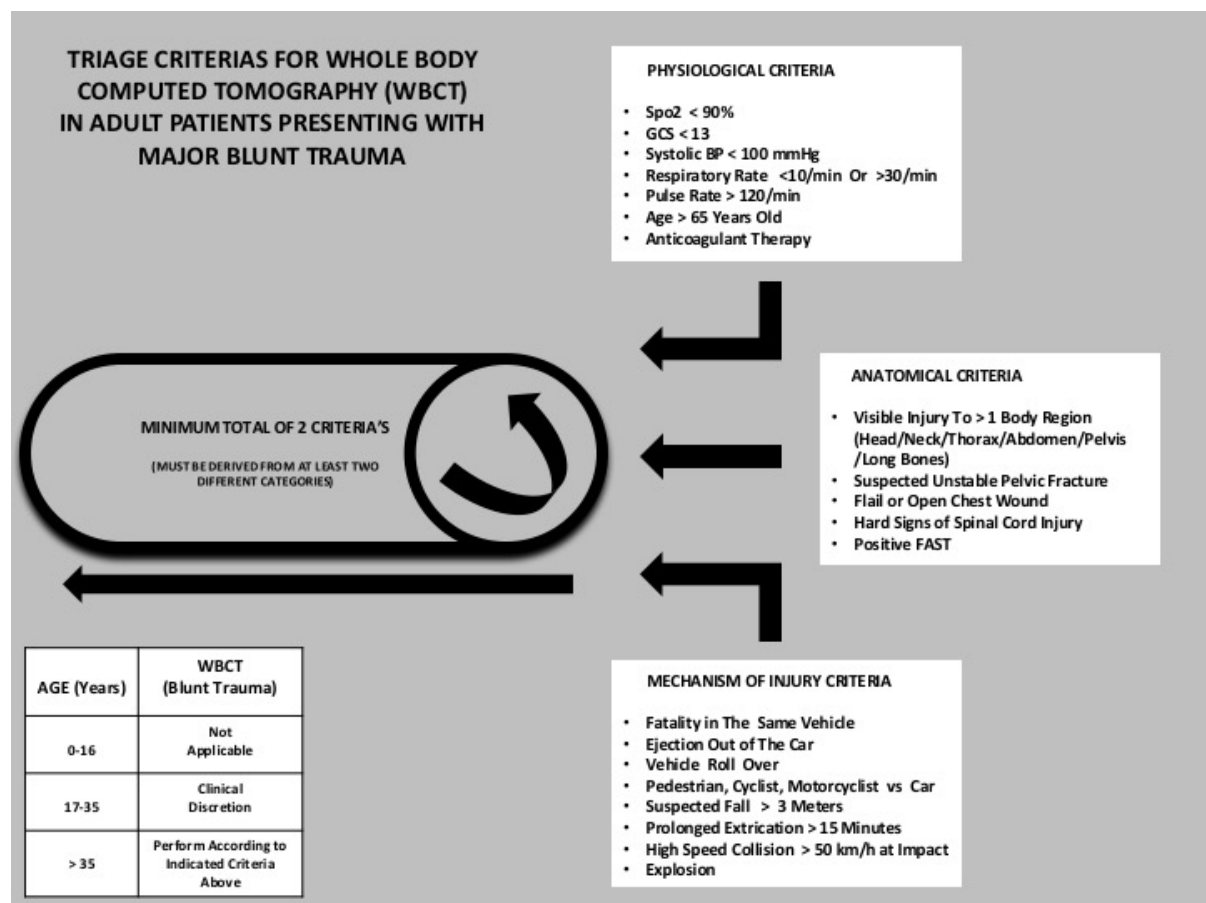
Proposed Whole Body Computed Tomography Triage Criteria for Adult Major Blunt Trauma Victims in Malaysia
